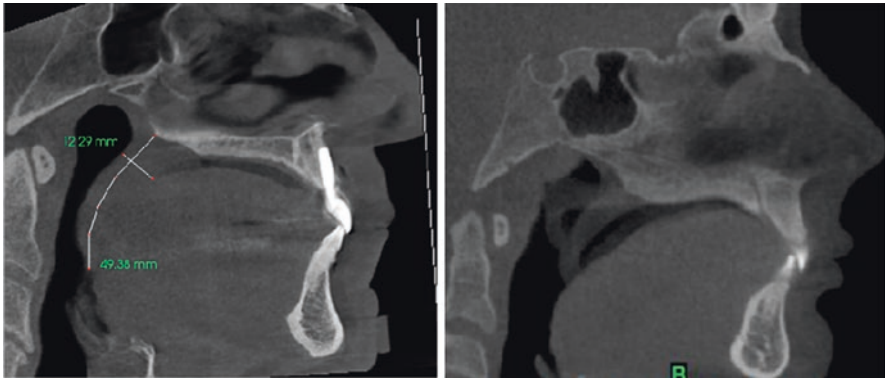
Sagittal CBCT shows the evaluation of the soft palate length from the posterior nasal spine to the tip of the uvula and the thickness in the thickest portion of the soft palate. Thickness is difficult to assess if the tongue is in contact with the soft palate as these two soft tissues cannot be differentiated on CBCT imaging. The patient should be instructed not to swallow to prevent soft palate elevation during scan acquisition (right)
